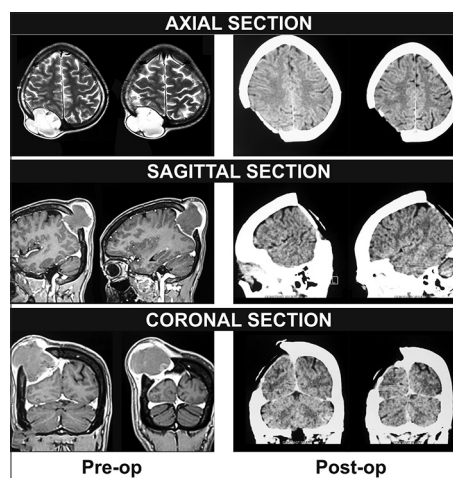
Pre-operative MRI of brain (plain and with contrast) showing a calvarial soft tissue lesion in the right parieto-occipital region with destruction of the adjacent parieto-occipital bone with intracranial extra-axial extension. Post-operative CT scan of brain (plain and with contrast) showing complete excision of the calvarial lesion
